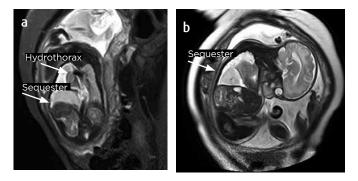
Patient of 24.5 weeks of gestation. MRI a) Sagittal STIR: Left pleural effusion (short arrow), decreased ipsilateral lung volume with diameters of 3.5 cm × 2.75 cm × 2.85 cm and volume of 14.6 cm 3, in relation to pulmonary hypoplasia. b) With coronal T2 information: Right infradiaphragmatic mass in the inferior and lateral aspect that shows intensity signal similar to the lungs (long arrow), measures 4.4 cm × 2.3 cm × 4.7 cm, volume of 24 cm3 with nutrient vessel from the aorta in relation to extralobar pulmonary sequestration.
